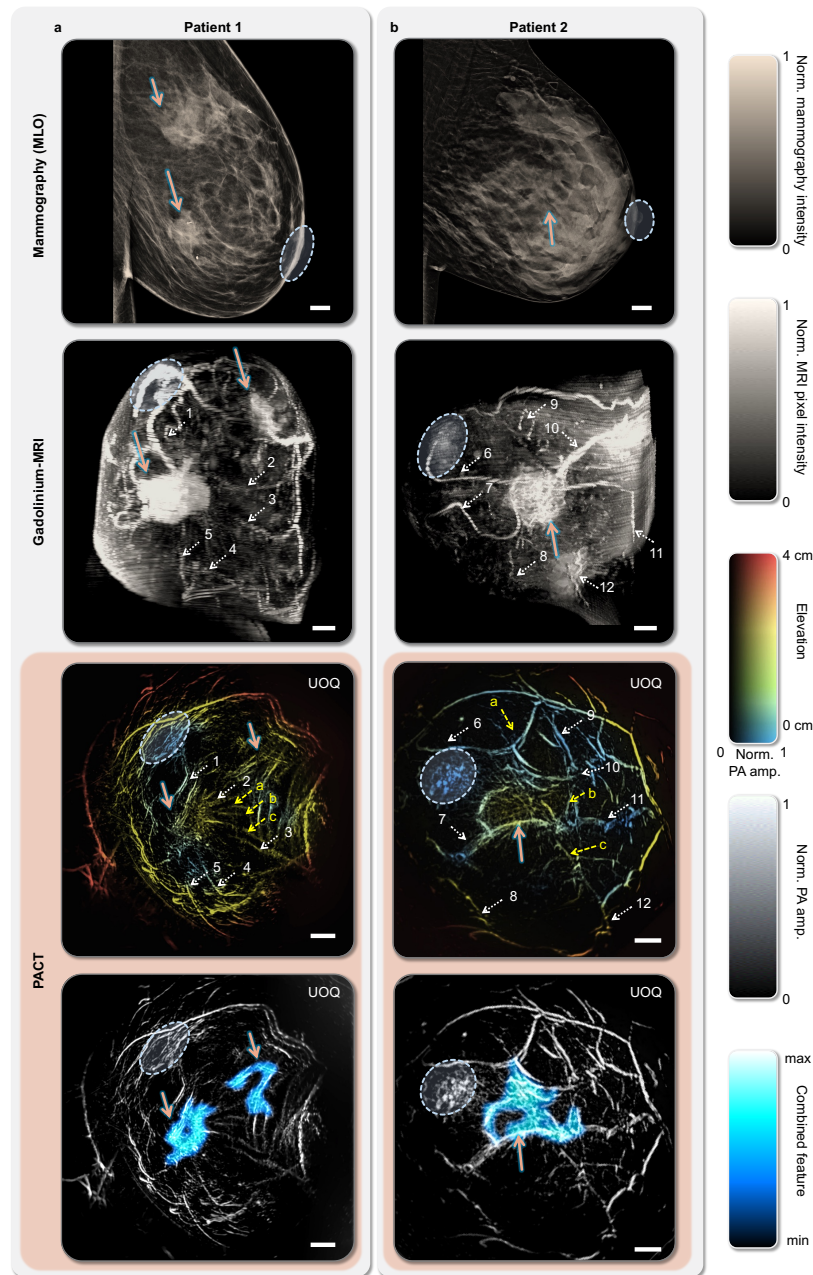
Representative breast images from PACT and conventional imaging modalities. (a–b) Mammography (top), gadolinium-enhanced MRI (2nd row), depth-encoded PACT (3rd row), and feature-encoded PACT (4th row) images of the same breasts in two patients with invasive ductal carcinoma (IDC). MLO, mediolateral oblique view. UOQ, upper outer quadrants. Lesions are marked by pink solid arrows. Vessels detected by both PACT and MRI are marked by white dotted arrows with numbers. Vessels detected by PACT only are marked by yellow dashed arrows with letters. Nipples are marked by light blue dashed contours. Scale bars, 1 cm.
